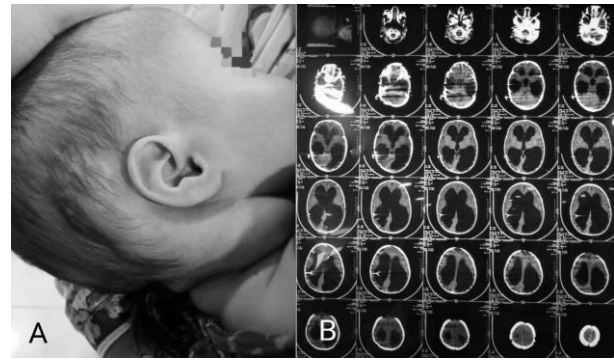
A: Surgical site swelling in a child with shunt blockade. B: CT Brain Plain of the same child with shunt blockade.
